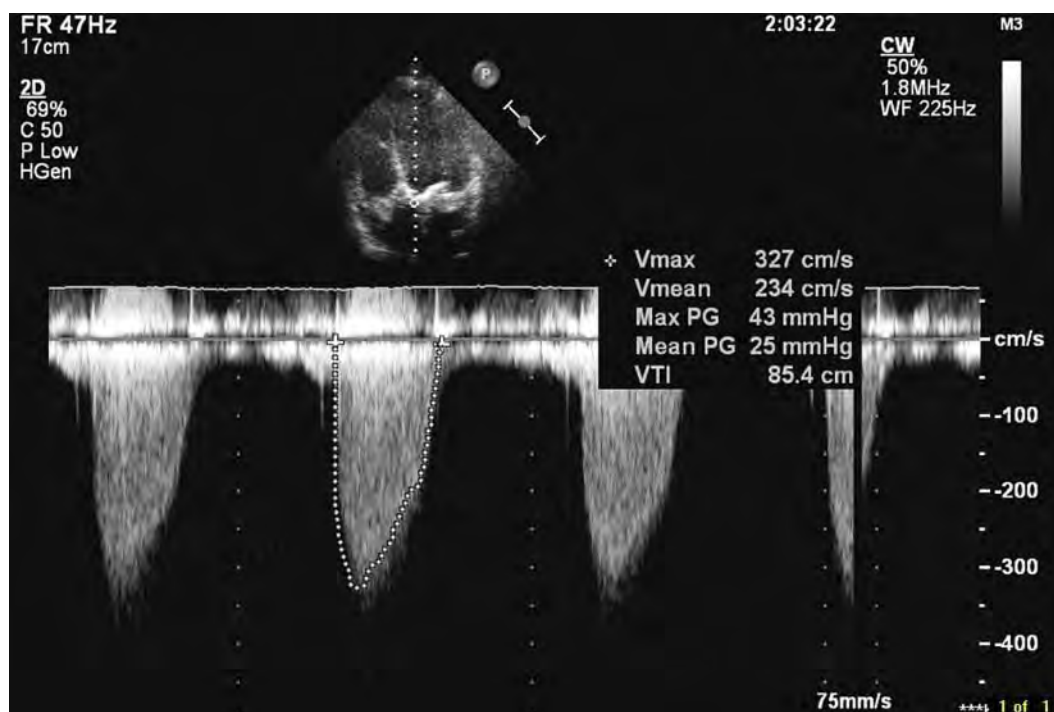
Continuous wave Doppler echocardiography. Doppler flow across stenotic aortic valve from the five-chamber view. The flow is accelerated (3.27 m/s) indicating a pressure gradient of 43 mmHg peak and 25 mmHg mean across the aortic valve.
